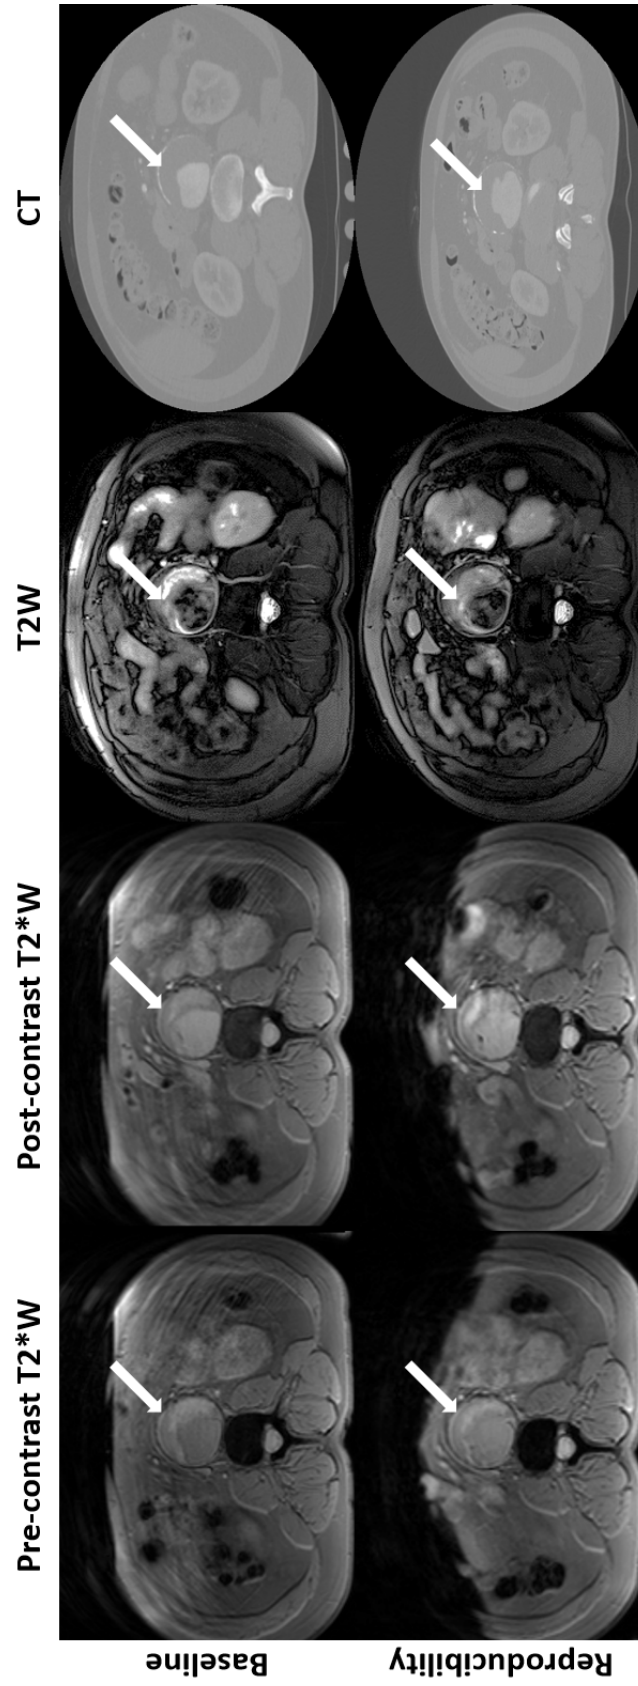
Example of axial MA³RS data acquired from the same patient in the baseline and reproducibility assessments: from left to right is pre- and post-contrast T2* weighted (T2*W) images, T2 weighted (T2W) image, and CT image. White arrows point to the aorta in different images. T2*W images shown in all figures of this chapter are acquired with shortest TE.
